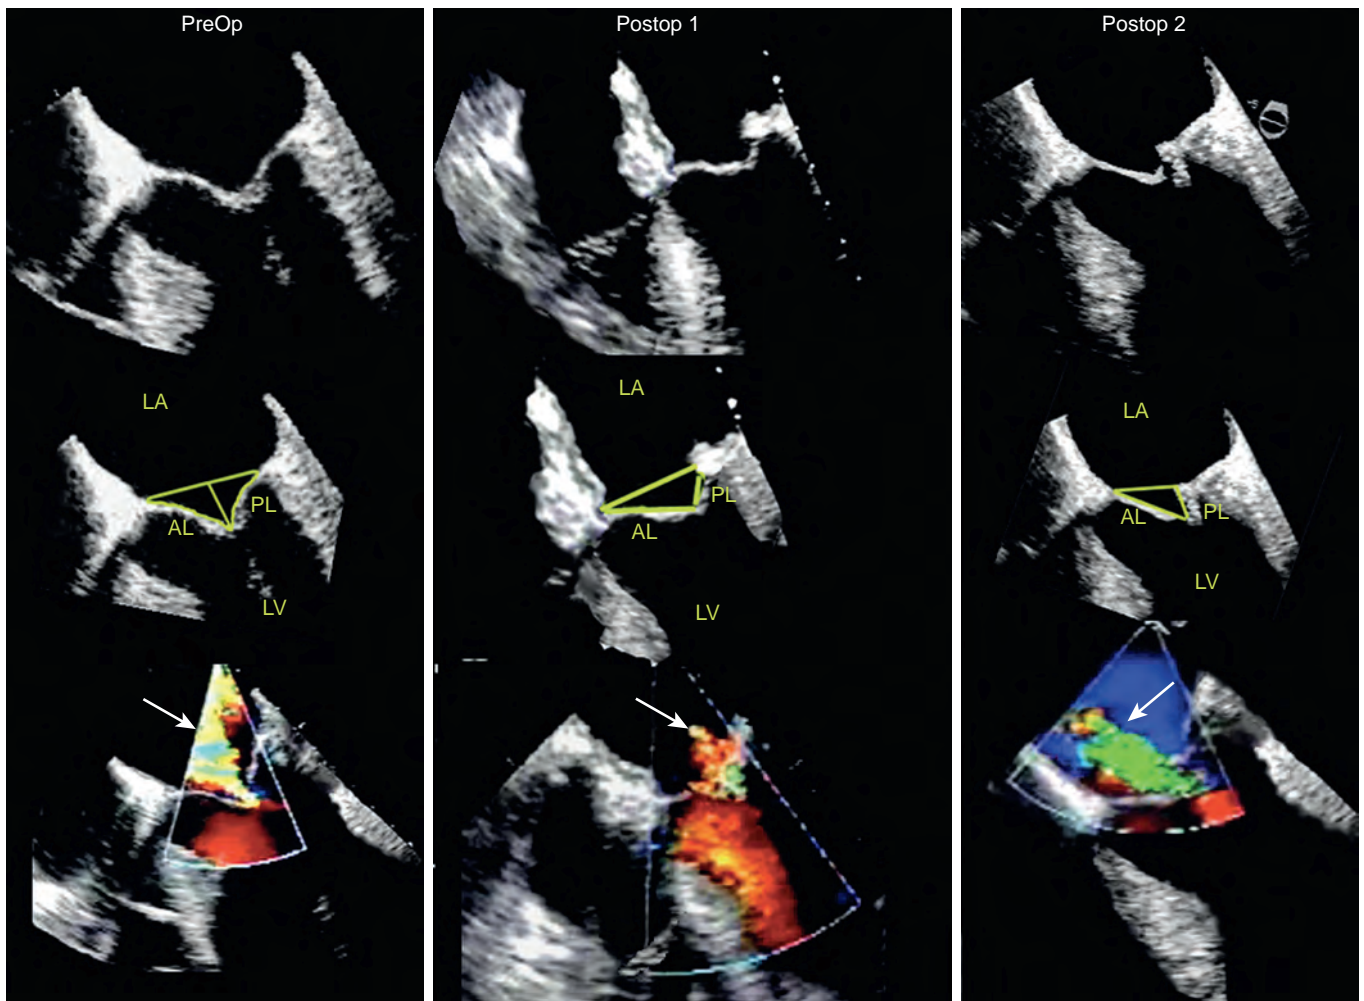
Repair of type IIIb mitral regurgitation (MR): annuloplasty. This case shows the preoperative, intraoperative, and second preoperative (reoperation) echocardiographic images. The preoperative images show the tethered leaflets (yellow triangle, middle figure) and MR (white arrow, lower image). After placement of an annuloplasty ring, the intraoperative images show a reduced tethering (yellow triangle, middle image) with reduced MR (white arrow). As is reported with repair of type IIIb MR, the images to the right show the recurrence of MR (white arrow). AL, Anterior leaflet; LA, left atrium; LV, left ventricle; PL, posterior leaflet.
